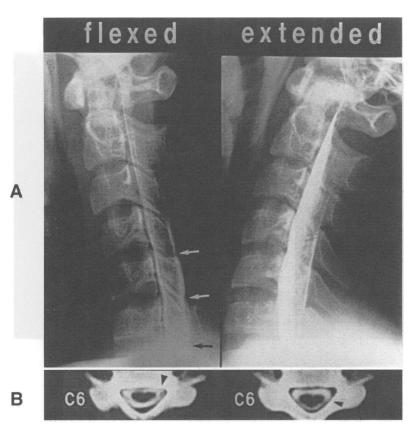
Myelograms and CT myelograms of case No 2 (the affected side is on the left). (A) Lateral view of myelograms. In neck flexion, the lower cervical cord and the posterior wall of the dural sac are shifted anteriorly, although the subdural space gets wider posterior to the cord (arrows). The posterior epidural space expands. In neck extension, the cord is moved posteriorly. As a result, the anterior subdural space gets wider and is filled more with contrast medium and the posterior epidural space is shrunk. (B) Transverse view of CT myelograms. In neck flexion, the cord is shifted anteriorly, being pulled to the affected side (arrow head) and flattened anteroposteriorly. As the posterior wall of the dural sac shifts anteriorly, the posterior epidural space expands. A space filled with the contrast medium between the cord and the posterior dura is seen. In neck extension, cuneiform atrophic cord is seen on the left side (arrow head) and the anterior subdural space is filled more with the contrast medium as the cord is moved posteriorly.
